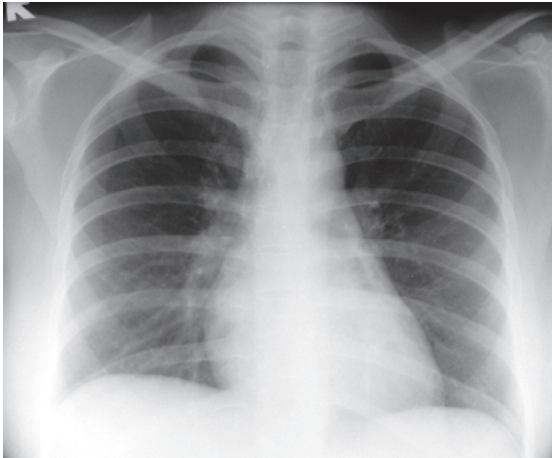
Repeat frontal chest radiograph shows resolution of the pneumomediastinum two weeks later.
